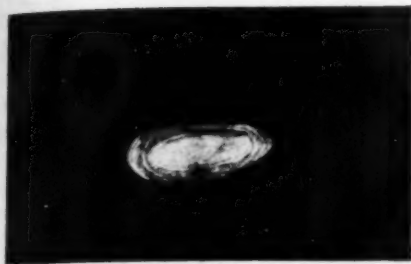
Case 9. Roentgenogram of laminated calculus found in appendiceal abscess.
